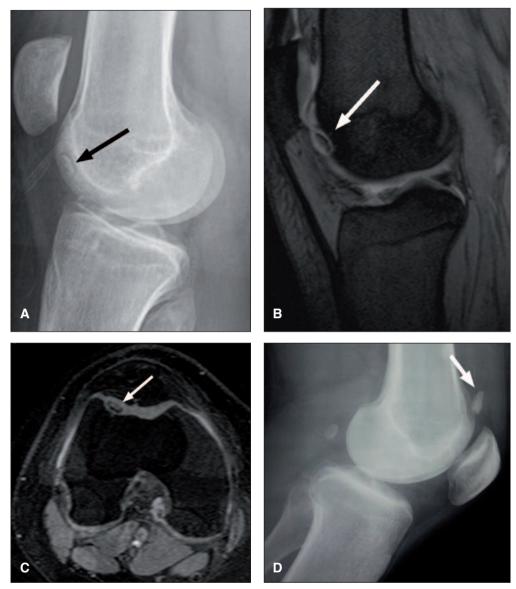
Lateral radiograph (A), sagittal MRI (B) and axial MRI (C) of osteochondritis dissecans lesion of the trochlea (arrow). The lesion is clearly demarcated from underlying subcondral bone with apparent anterior separation of articular surface. D: Lateral radiograph showing a loose body (arrow).
